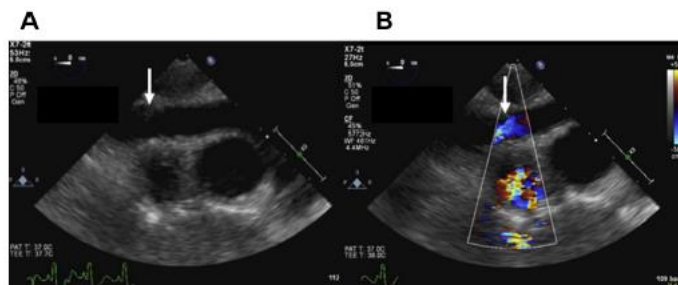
Midesophageal ascending aorta short axis view with the probe turned toward the right showing (A) the right pulmonary artery and (B) with color flow Doppler. The arrow marks the most likely area of anastomosis.
